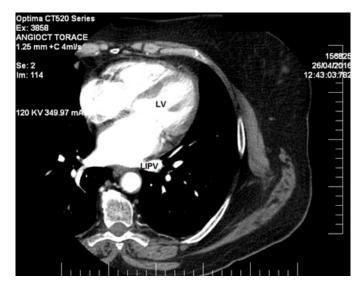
Computed tomography of the left atrium. In order to differentiate between LSPV and LIPV the left atrial appendage or the left ventricle is searched. The vein that is seen in the same plan with LV is the LIPV.
